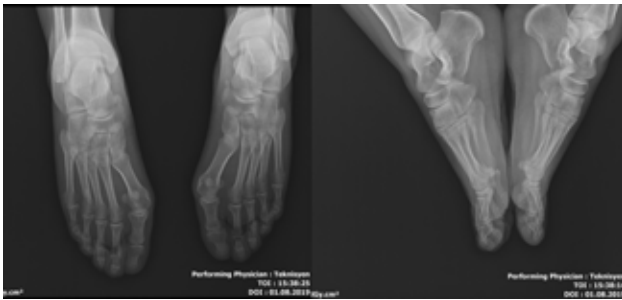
Preoperative radiographic images of a 33-year-old male patient with HV treated with cannulated screws.
